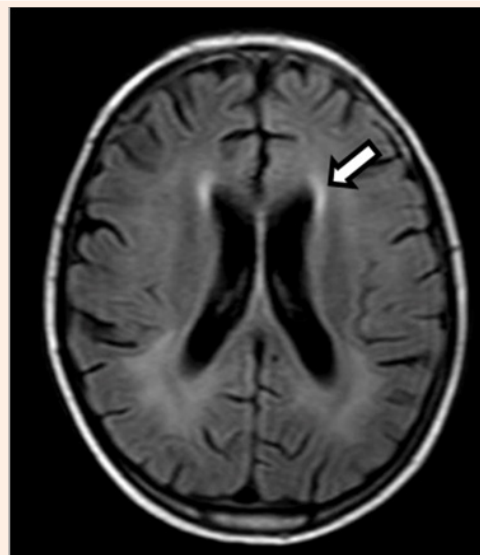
Flair magnetic resonance imaging (MRI) of the brain showing signal intensities in the periventricular area (arrow), mild volume loss of the cerebral white matter involving the periventricular and subcortical white matter.
